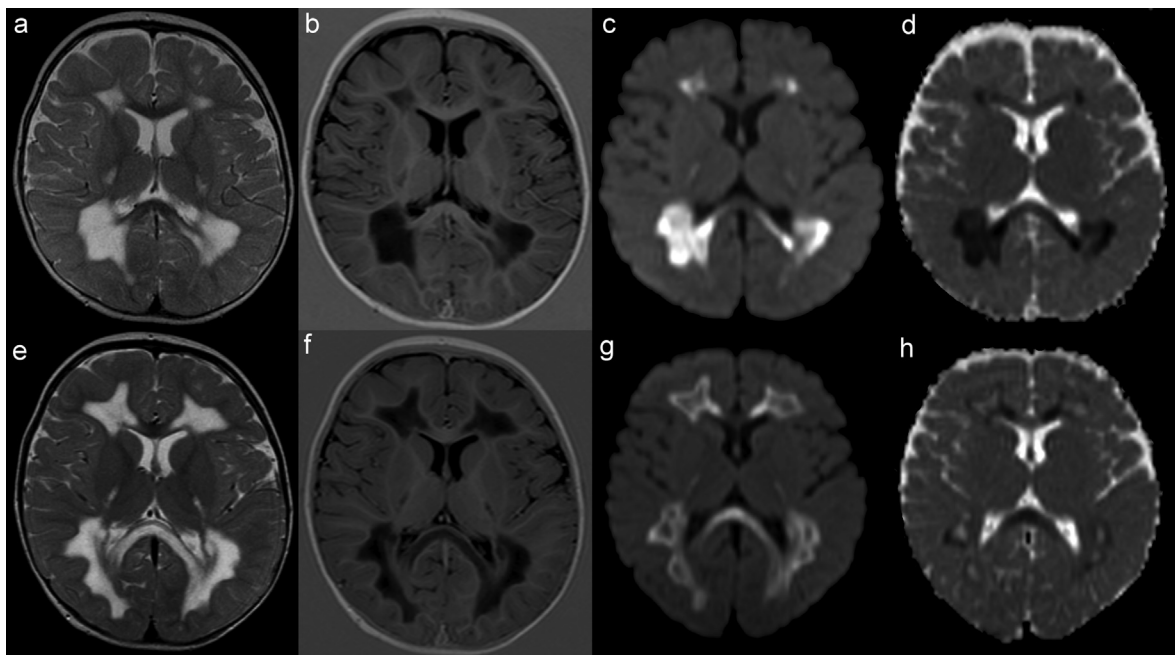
Comparison of MR images of our patient at 11 (a–d) and 15 months of age (e–h). T2-weighted (a, e) and T1-weighted inversion recovery (b, f) images show bilateral symmetric signal changes mainly affecting periventricular and central white matter. These changes show a centripetal pattern of progression on follow-up. In addition, posterior limbs of internal capsules and corpus callosum are affected; U fibres are spared. Diffusion weighted imaging (c, g) and apparent diffusion coefficient [ADC] (d, h) show areas of restricted diffusion which also progress towards the periphery.
